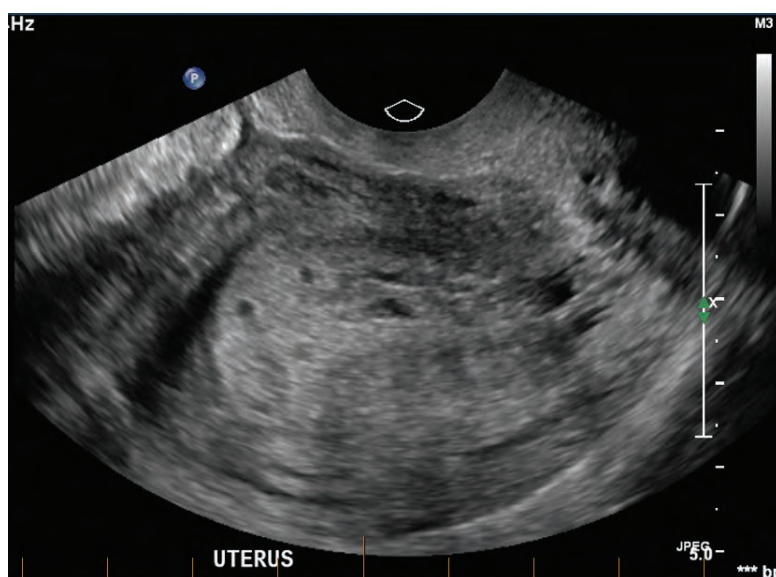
Ultrasound findings consistent with gestational trophoblastic disease.
